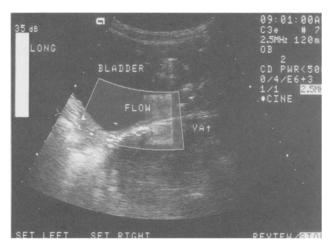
Longitudinal suprapubic ultrasound view of the same patient as in Fig. 3.
